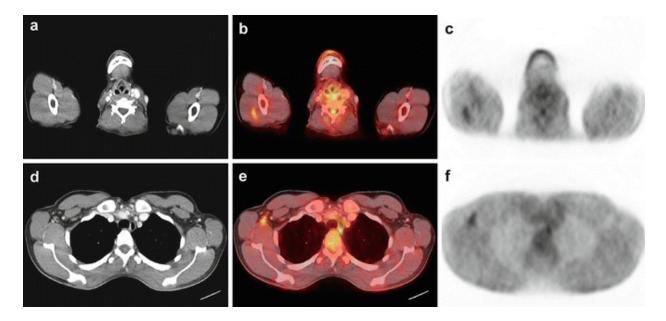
Female patient suffering from metastatic breast cancer. Contrast-enhanced CT, fused PET/CT, and PET images of the right upper arm (a-c) and the axillary region (d-f) are displayed. Increased tracer uptake can be noted in the right deltoid muscle (b-c) and in the non-enlarged right axillary lymph
